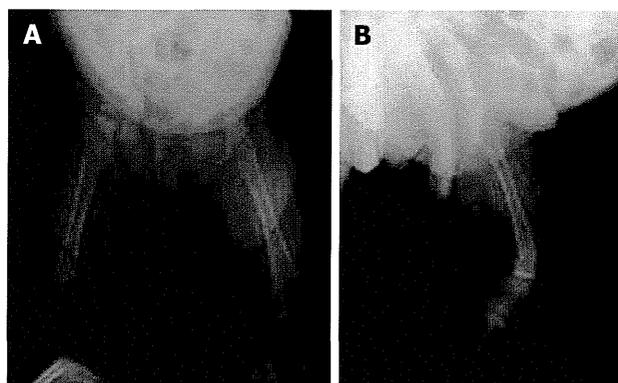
Plain skeletal radiographic features at the 28 d after hepaticojejunostomy in the case 2. Anteroposterior (A) and lateral (B) plain radiographs showing a displaced fracture (arrows) of the left distal femur.
